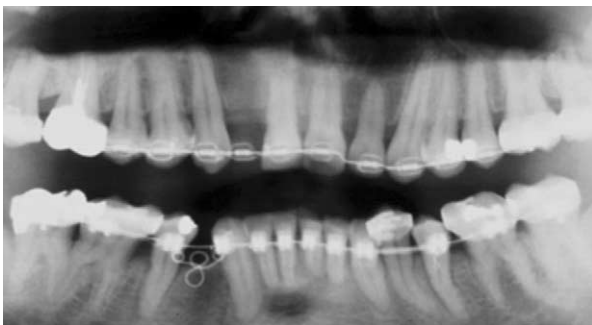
Progress radiograph.
